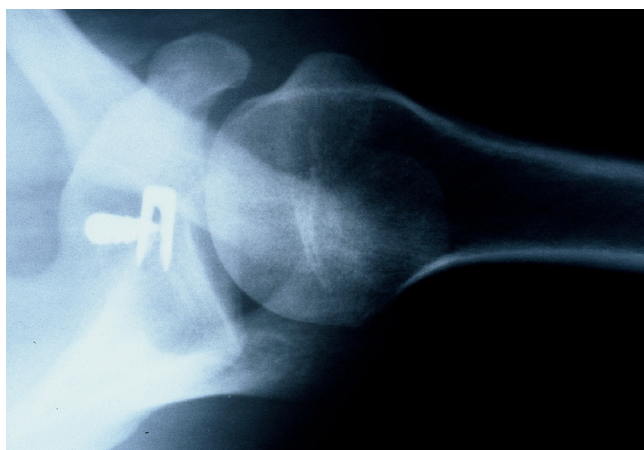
Postoperative radiograph after staple capsulorrhaphies.
